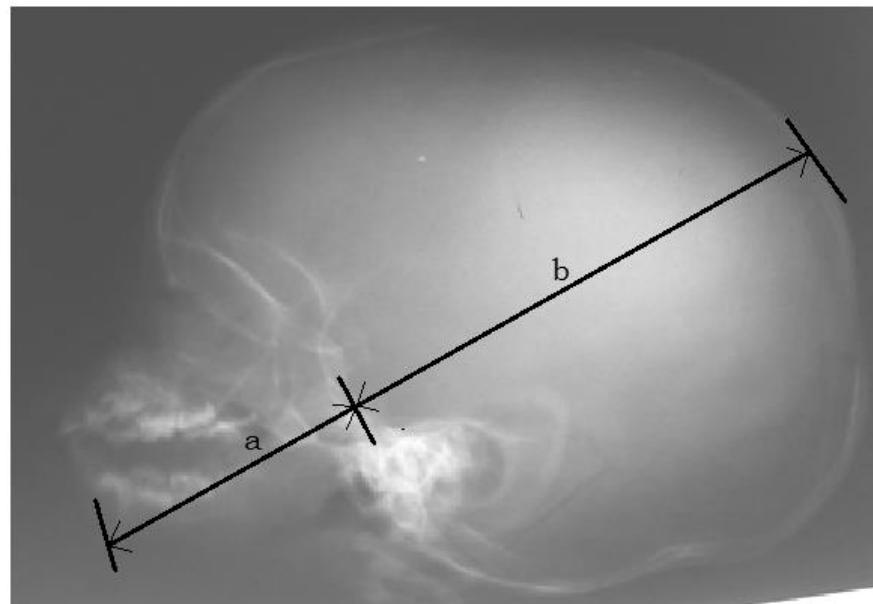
Skull radiograph showing how to measure craniofacial ratio.
